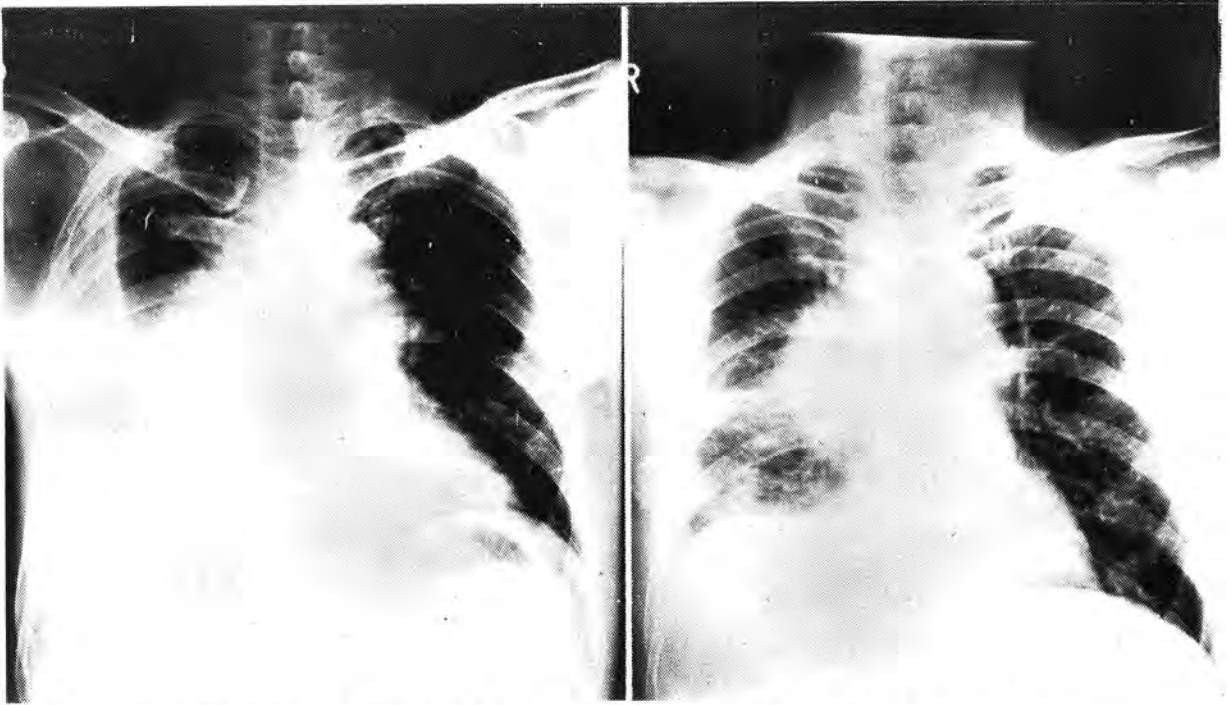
These x-rays belonged to a 63-year old man with very strong circumstantial evidence of lung cancer. However, all investigations short of open biopsy did not reveal any malignancy. He was finally proved at exploratory thoracotomy and direct biopsy to have primary amyloidosis.
